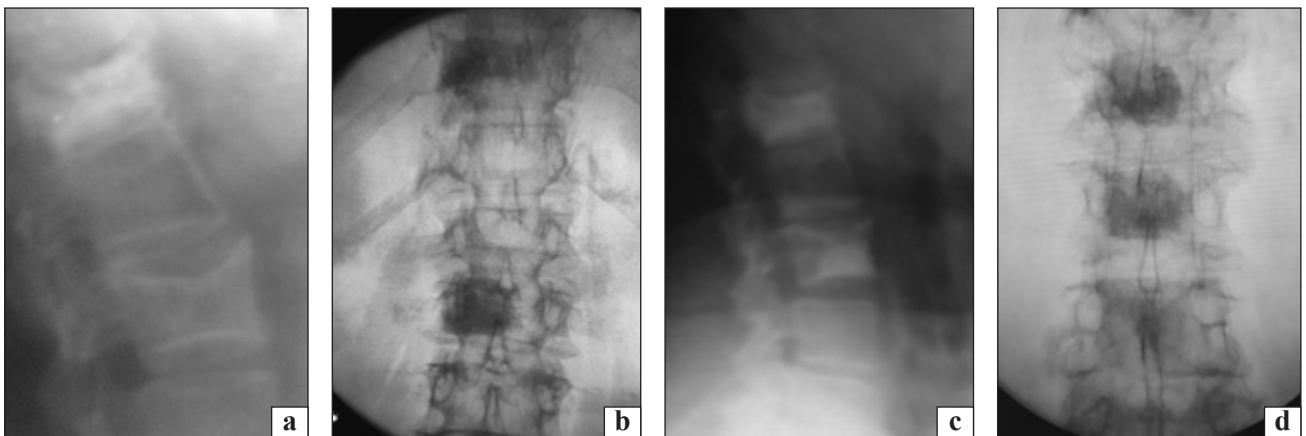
Photographs of radiographs of a 69-year-old patient K.. Diagnosis: compression fracture of the L_{III} vertebra secondary to osteoporosis. Condition after puncture vertebroplasty of the L_I vertebra (before surgery (a, b), after surgery (c, d))
